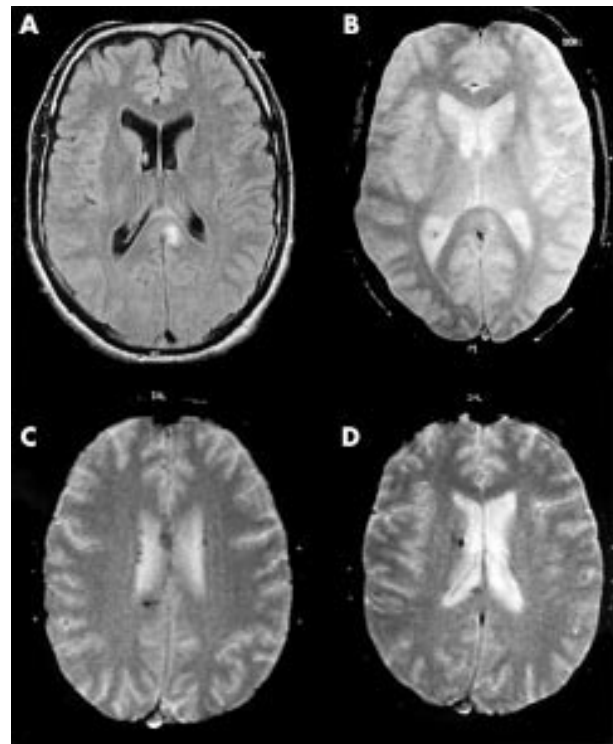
Grade II diffuse axonal injury (DAI). Patient 1: 26 year old man, one week post-traumatic amnesia (PTA) after a fall skiing. Fast fluid attenuated inversion recovery (FLAIR) image (A) showing signal abnormality in splenium of corpus callosum to left of midline; corresponding T2* gradient echo sequence (B) shows no evidence of susceptibility at this site, in keeping with a non-haemorrhagic lesion. Patient returned to work with minor constraints. Patient 2: 32 year old male, three months PTA, community independent, not working. T2* susceptibility effect representing blood products in the subependyma, mid and right posterior body of the corpus callosum, and subjacent to the superior frontal gyri (C, D). Normal T1/T2 weighted sequences.
